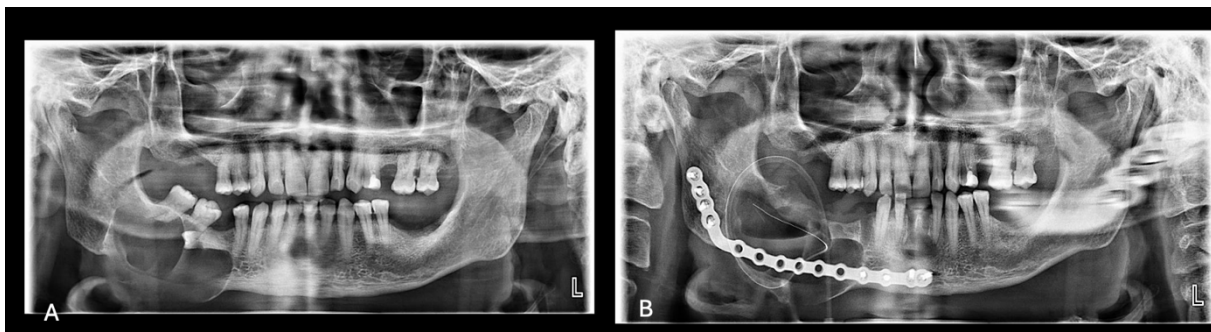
(A) Mandibular lesion with perforation extending close to the basal border, indicating a high risk of fracture. (B) Postoperative panoramic radiograph following surgical management and reconstruction plate application.
